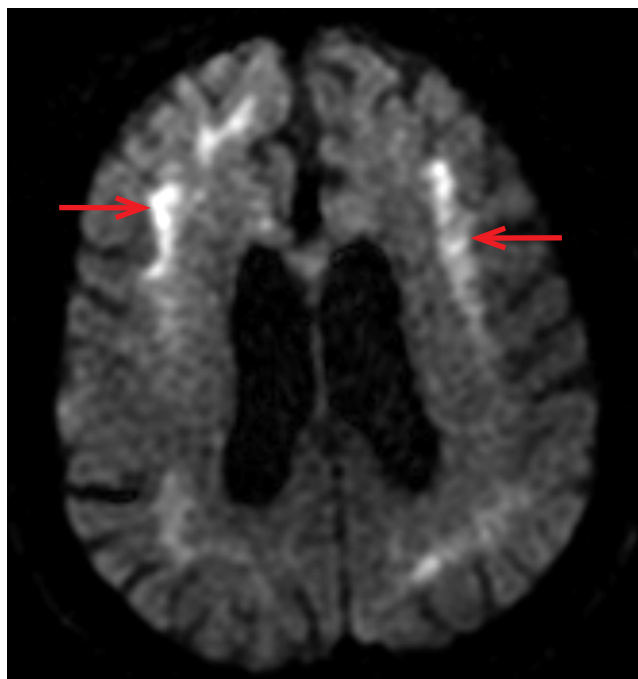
Symmetrical DWI-hyperintensity at the level of the corticomedullary junction on both sides at the frontal (arrows) and parietal lobes.
